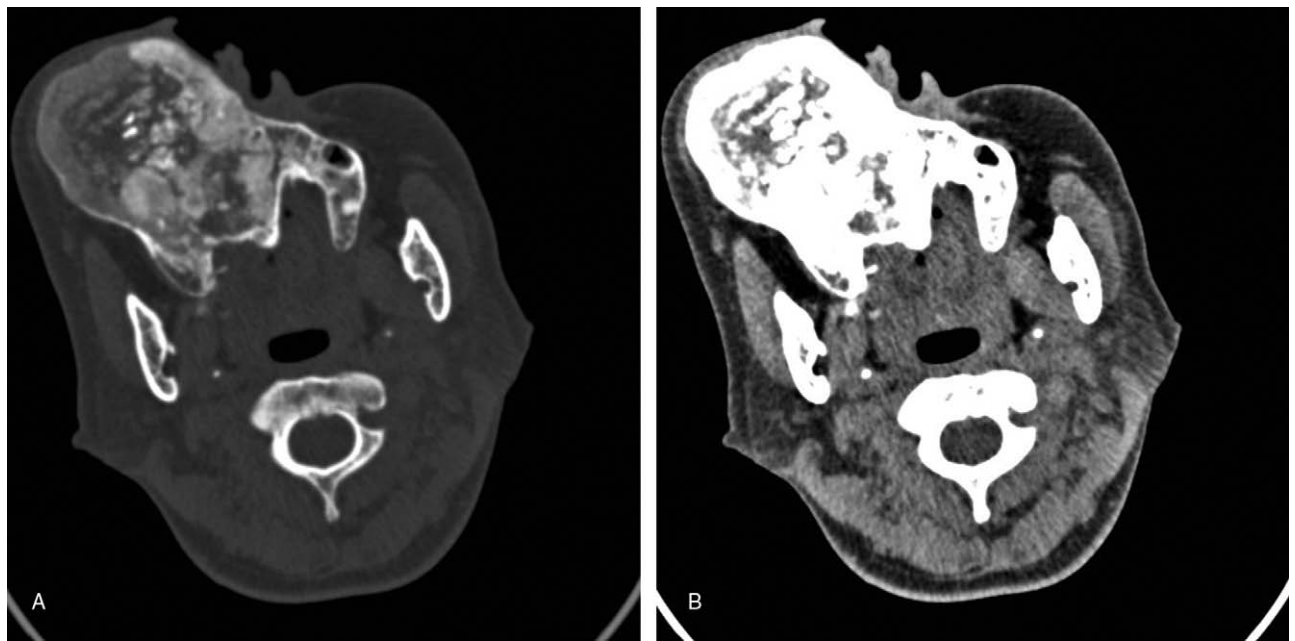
(A, B) Bone and soft tissue window of computed tomography axial view shows a well-defined lesion with radiolucent and radio-opaque foci.
